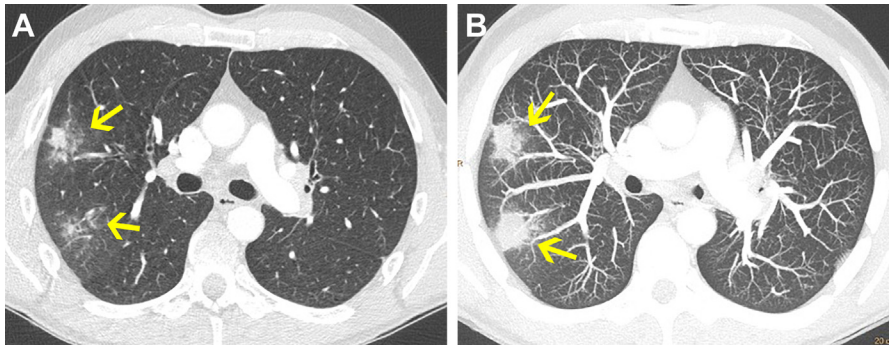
Nocardial pneumonia. (A) CT at the level of the carina shows peripheral subpleural ill-defined nodules with surrounding ground-glass opacity (arrows). (B) On the thin maximum intensity projection reformatted image an associated halo sign is clearly demonstrated (arrows).
